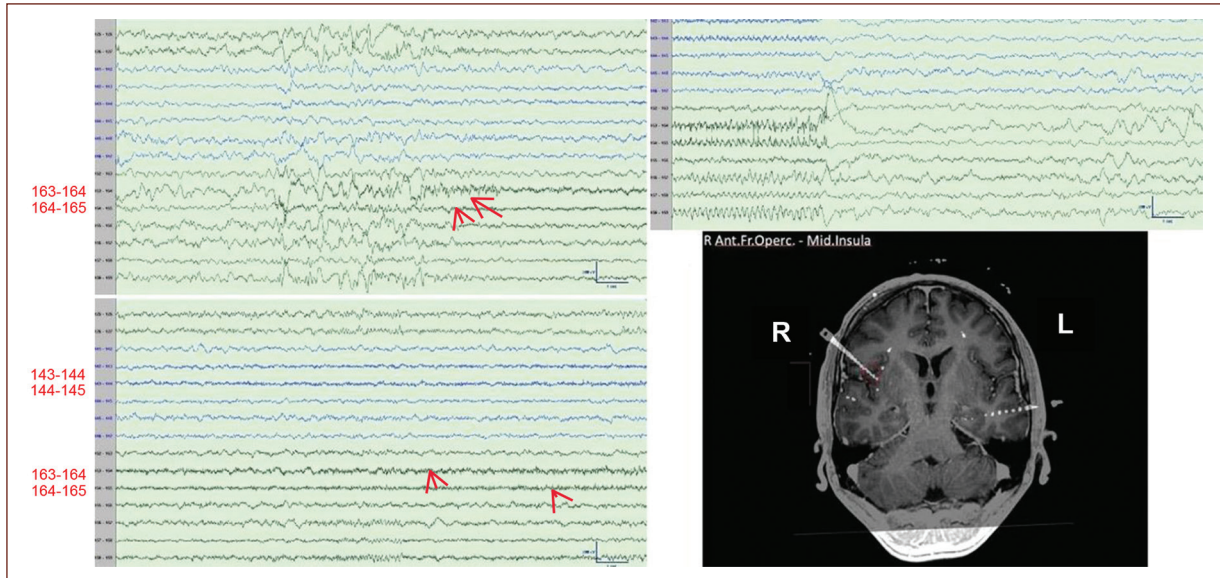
Intracranial electrode recording (left) shows a seizure focus within the right frontal opercular area (see MRI correlate on the right). Note seizure onset at electrodes 163, 164, and 165. Settings: LFF = 1 Hz, HFF = 75 Hz, Notch Filter Off, Sensitivity = 10 $\mu\text{V}/\text{mm}$.
